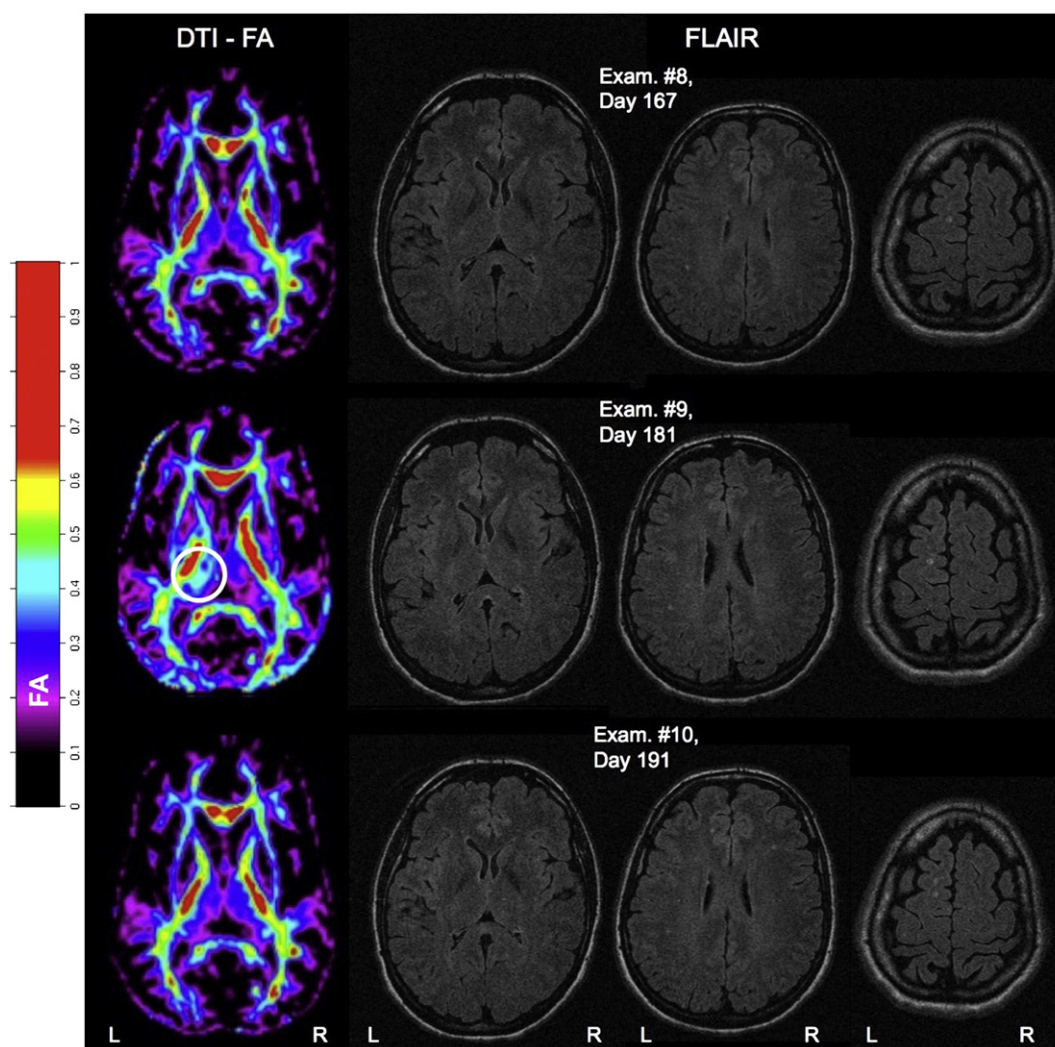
Comparison of DTI (column 1) and FLAIR MRI (columns 2–4). The slices were taken on examination #8 (row 1), #9 (row 2), and #10 (row 3). The slice position of the FA image almost corresponds to the FLAIR section shown in column 2. While the FA image taken on examination 9 demonstrates increased FA in the left thalamus (white circle) during the episode of central pain, the corresponding FLAIR (column 2, row 2) appears completely inconspicuous. The three FLAIR slices include all lesions found in the patient's brain, including brain stem and whole spinal cord. The latter was imaged separately.
